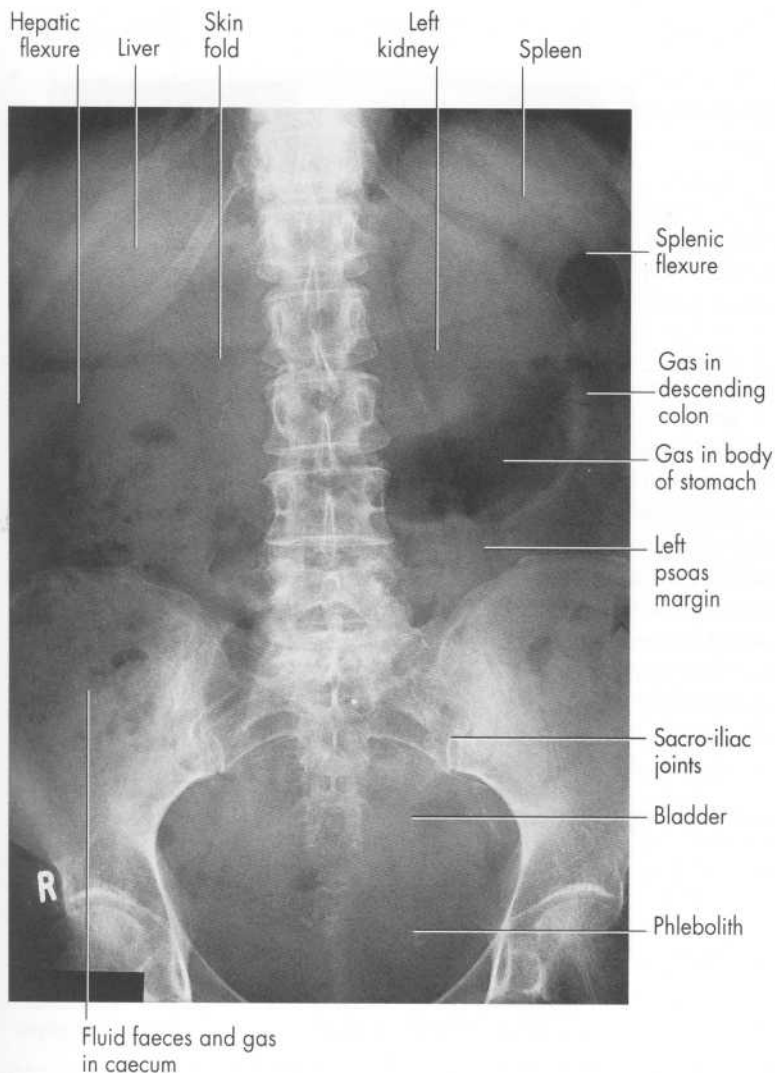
Adult supine AP radiograph in a 55-year-old woman.
